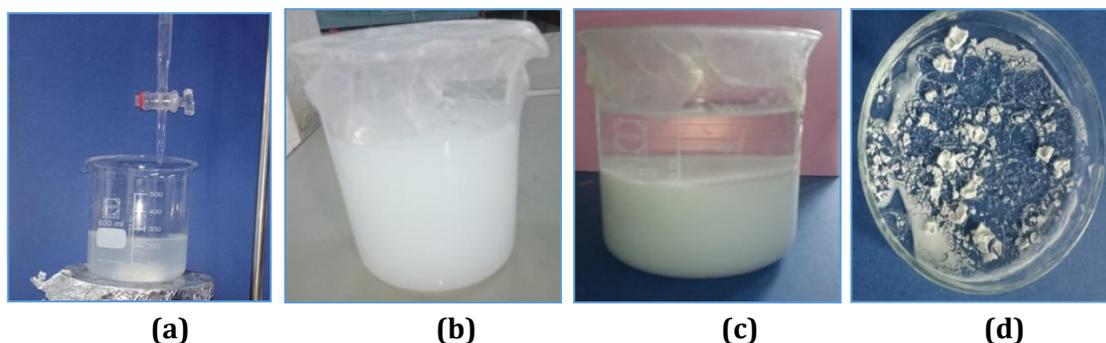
The main steps of synthesis of ZnO NPs, (a): mixture under ultrasound, (b): before maturation, (c): after maturation, (d): dried sample
